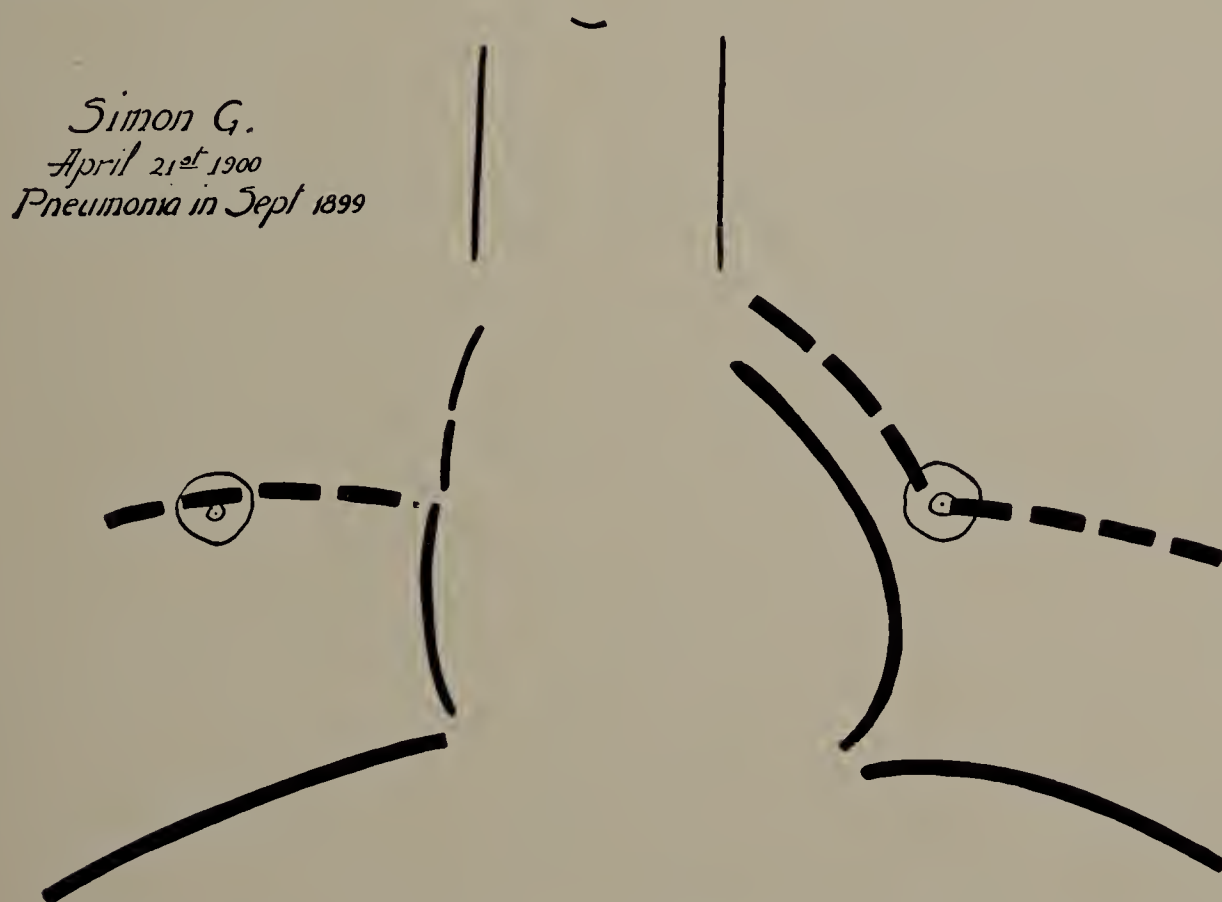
Simon G. April 21, 1900. Fourth X-ray tracing. (One-third life size.)
